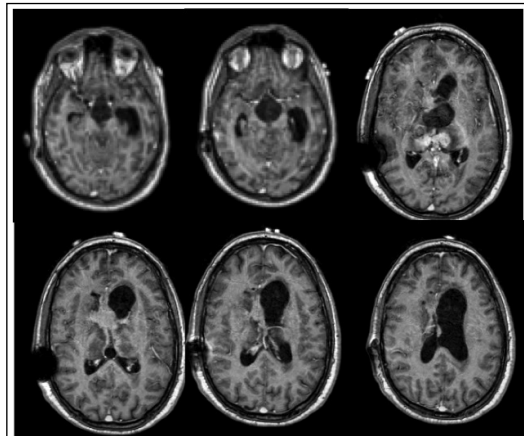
Pre-operative axial T1 post-contrast MR images in a case of intraventricular germinoma with multiloculated hydrocephalus
